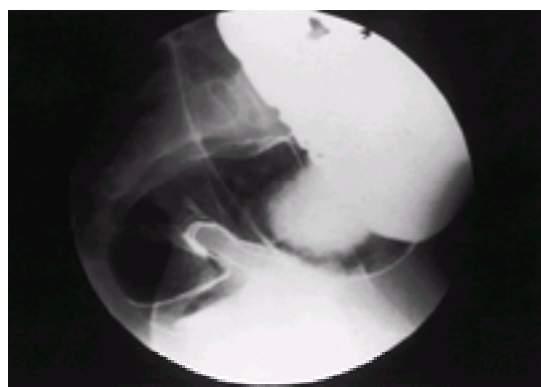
Lateral radiograph of the pelvis. Barium enema demonstrating the narrowed area in Hirschsprung's disease at the junction with the aganglionic segment.
